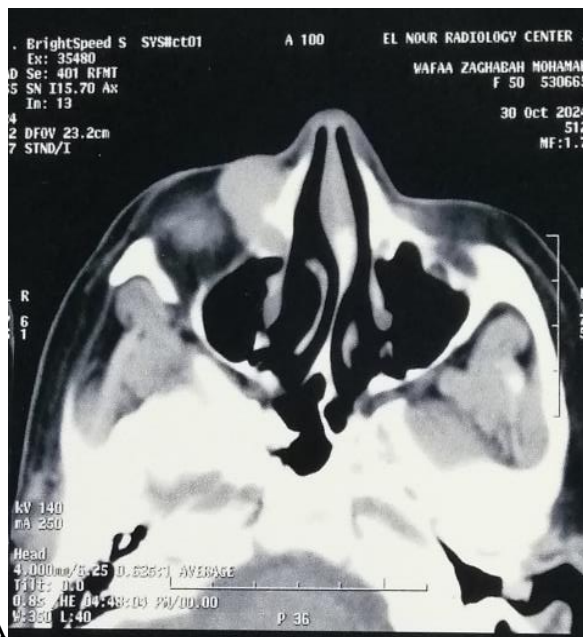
CT nose paranasal sinus. (A) axial view, (B)coronal view shows right dacryocystocele.
